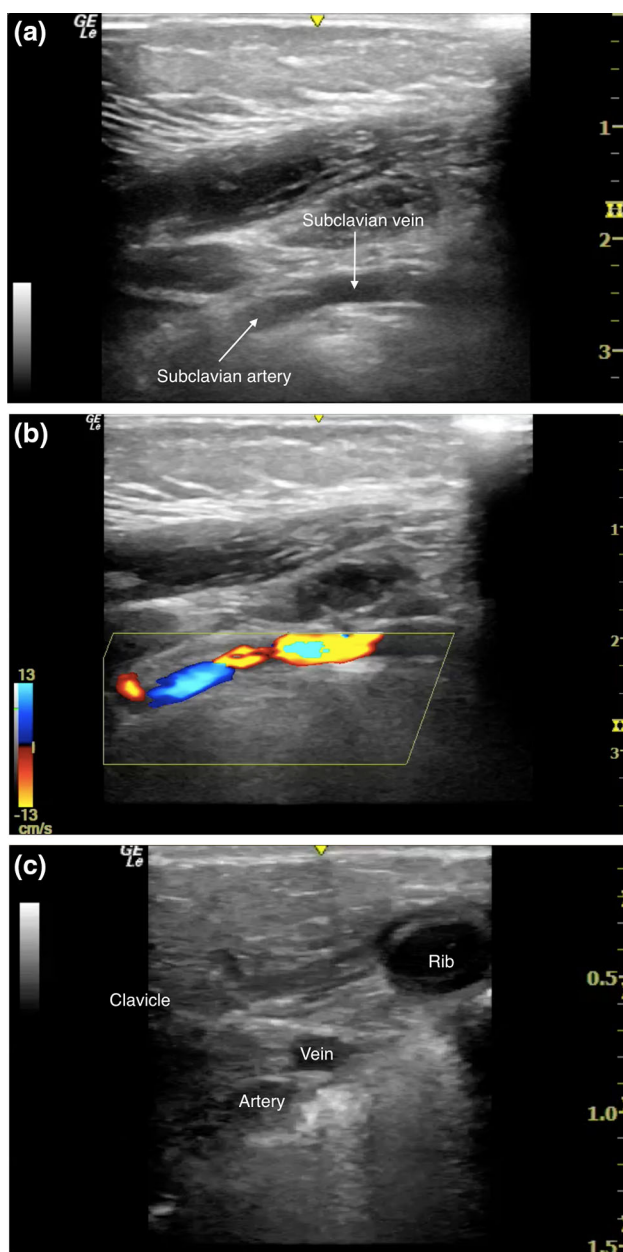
a) A linear view of both the subclavian vein and artery can be seen nearly contiguously because of the arc of the vessels through the imaging plane (b) with colour-flow Doppler (c) shows a transverse view of the vessels
